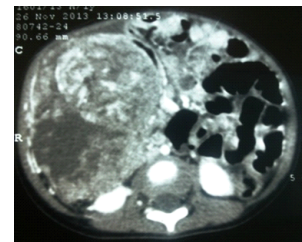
CT picture of right sided Yolk Sac Tumor.
